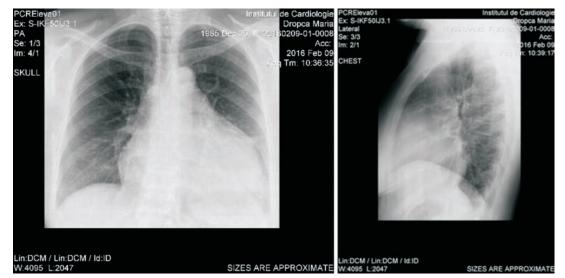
Thoracic radiography of the patient.
